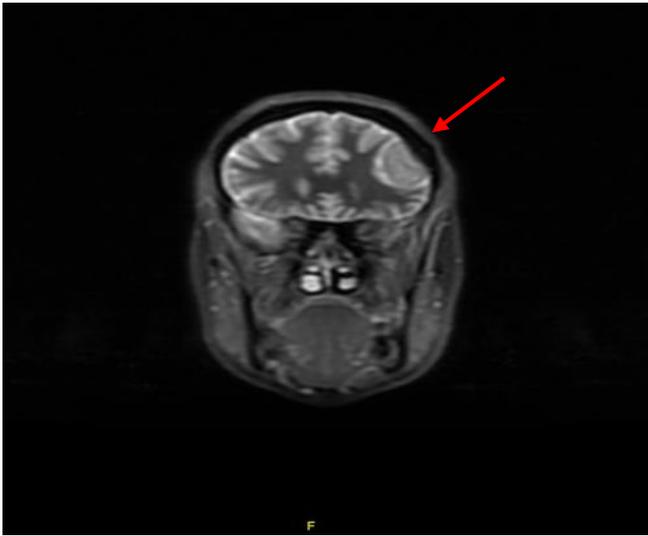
WB-MRI, T2-weighted sequence, is a smoothly contoured lesion in the left frontotemporal region in the cranial coronal section, primarily compatible with meningioma (red arrow).
